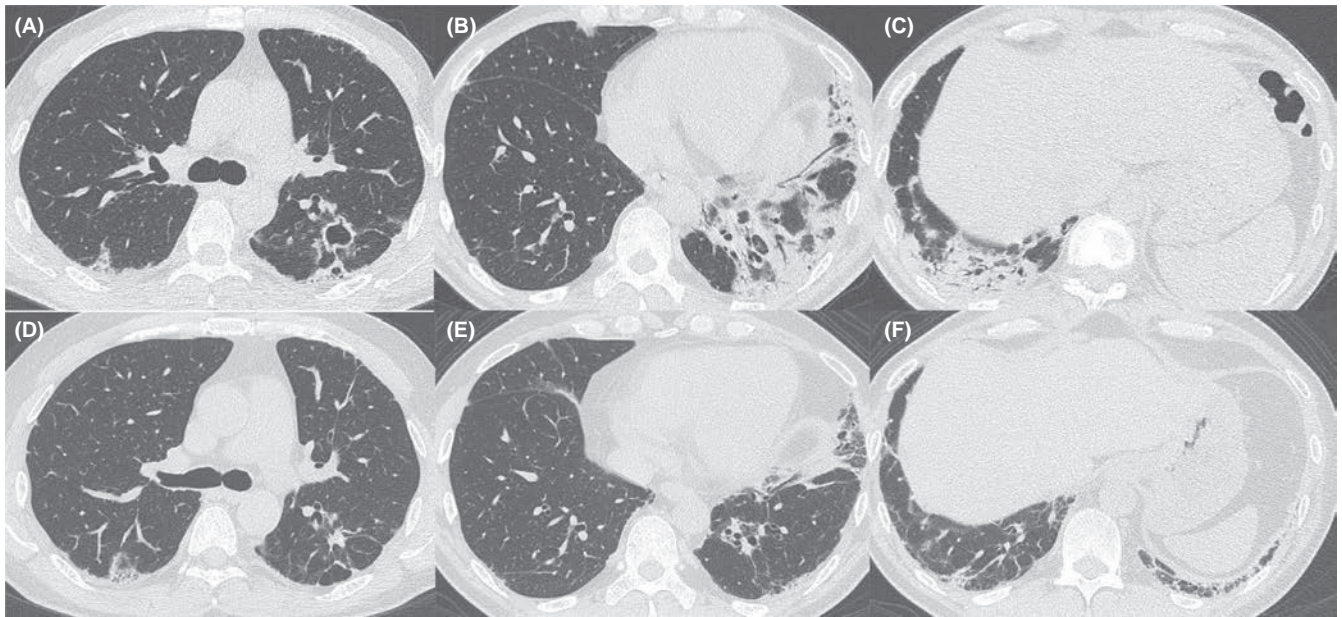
A, Chest computed tomography (CT) on admission shows a cavity on the left S1 + 2. B, C, Chest CT on admission shows ground-glass opacities in the bilateral lower lung fields. D-F, Chest CT on the 60th day of hospitalization shows improvement after treatment
